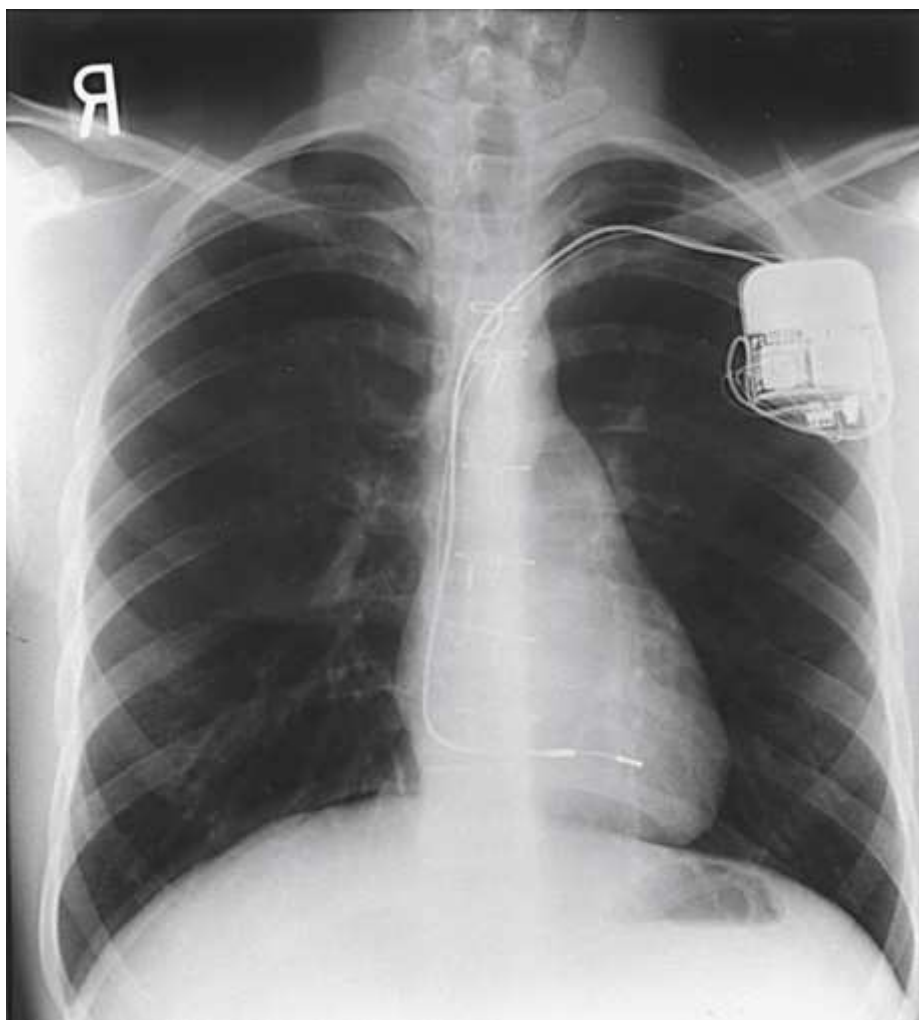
Chest radiograph of a patient with a permanent pacemaker implanted. Note the pacemaker location in the superior and anterior chest wall, with the distal leads located in the right ventricle and right atrium of the heart.
